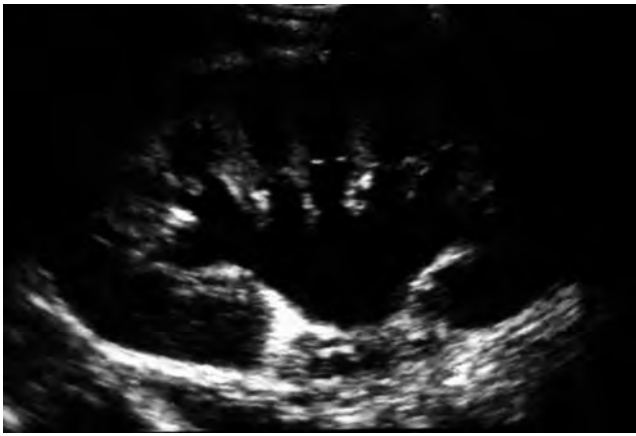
Classic ultrasound image of ureteropelvic junction obstruction, with dilated renal pelvis and infundibula and calyces. The ureter is not visualized in this image.
